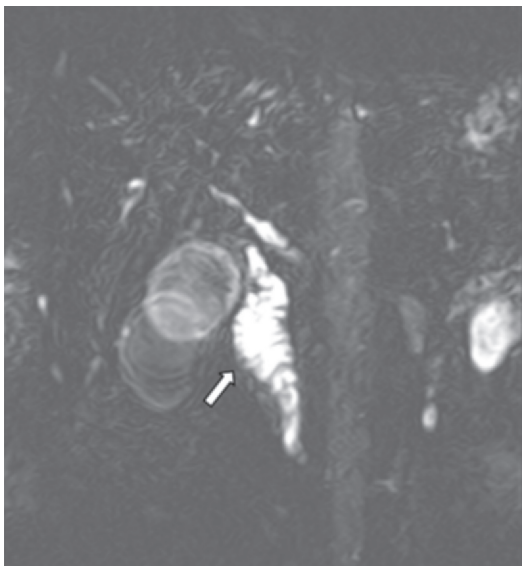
Cholangio-magnetic resonance imaging showing dilation of the pancreatic duct (arrow).
